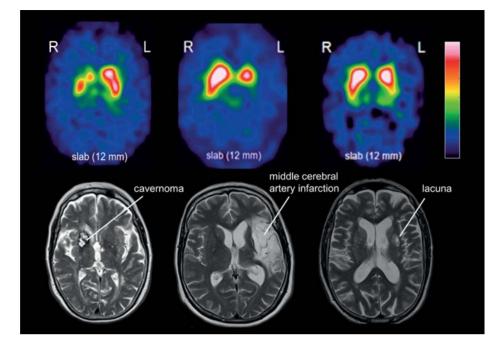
Atypical patterns of findings on DAT-SPECT—for example, reduction of tracer uptake more pronounced in the caudate nucleus than in the putamen—are often caused by vascular lesions. Depending on their localization, vascular lesions can also cause patterns of findings that on DAT-SPECT alone cannot be differentiated from nigrostriatal degeneration. DAT-SPECT should therefore by interpreted in tandem with up-to-date structural images, preferably MRI.
